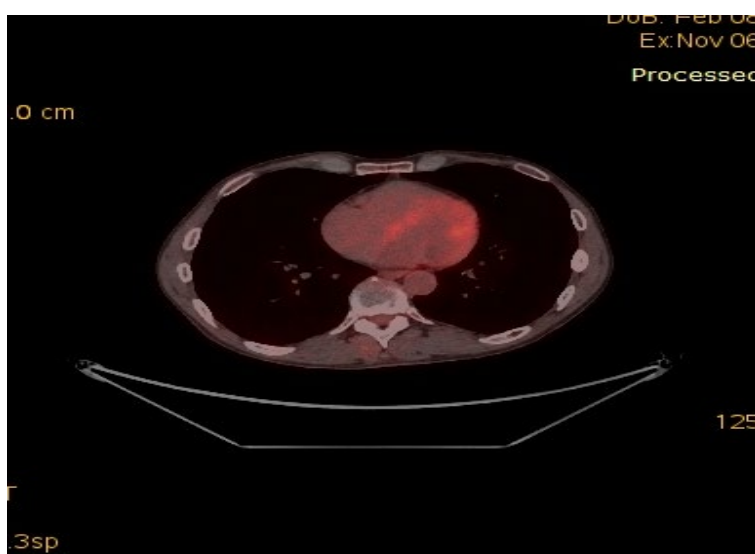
PET-CT: Para-aortic Nodule
